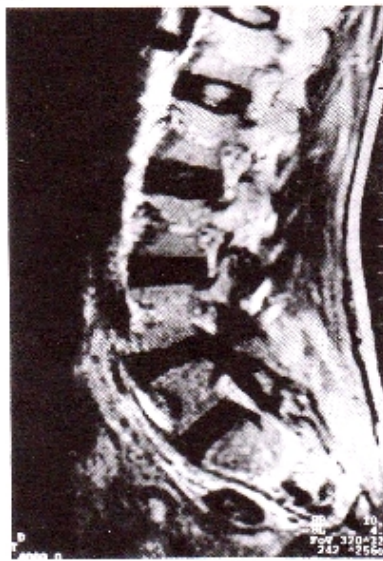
Preoperative T2 weighted sagittal lumbar MRI
